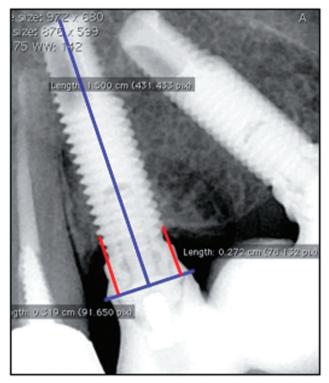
Each radiograph was calibrated by using the known length of the implant as reference.
